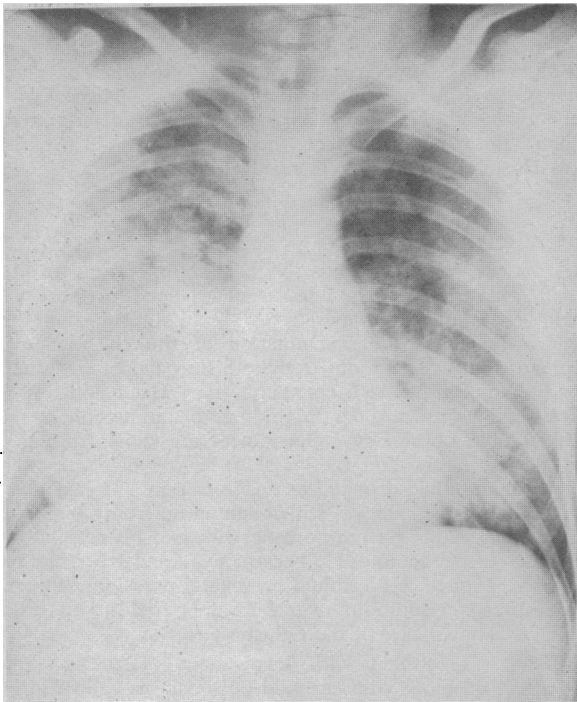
Case 1. Chest x-ray appearances on admission.
